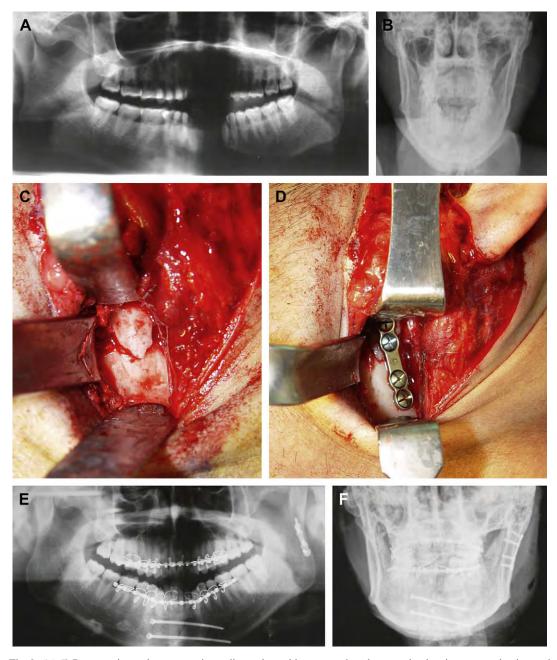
(*A–F*) Preoperative and postoperative radiographs and intraoperative photographs showing open reduction and internal fixation of left subcondylar fracture by way of the facial rhytidectomy approach.
